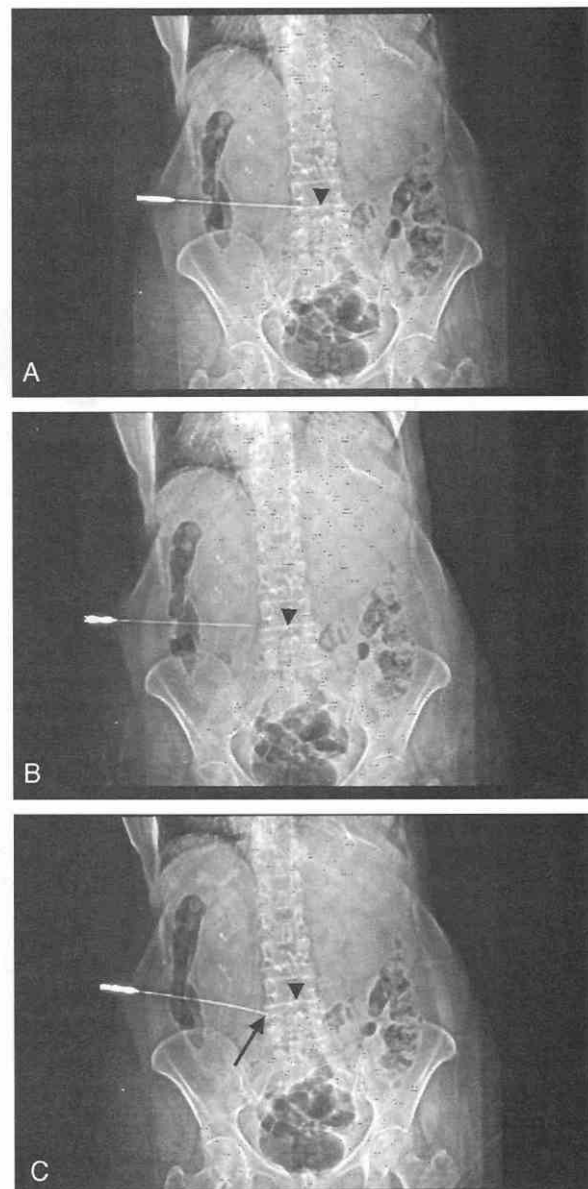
These three radiographs (A to C) show the position of a needle tip that is moved by the deflection method (see text). Note in the first radiograph (A) the needle tip is adjacent to the lower end plate of the L4 body. In B, the needle has been retracted back slightly before the deflection maneuver. The skin was retracted and the bevel rotated cephalad as noted above and the needle was pushed forward. In C, one can see that the needle tip (arrow) was deflected caudally almost 10 mm to the top of the L5 end plate.
